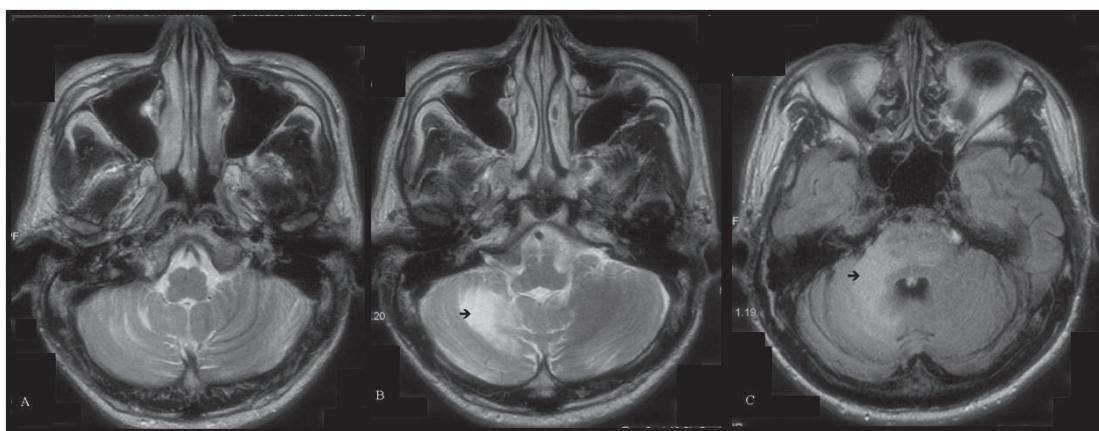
MRI (1.5 Tesla) examination at onset of symptoms prior to HAART. Axial T2-weighted images (TR/TE 832ms/25ms) and FLAIR, (A) & (B) at the level of medulla, and (C) at pons. Arrows pointing to the high signal intensity lesions at the right side of cerebellum and right middle cerebellar peduncle and with absent mass effect. These lesions do not enhance on post contrast images.
